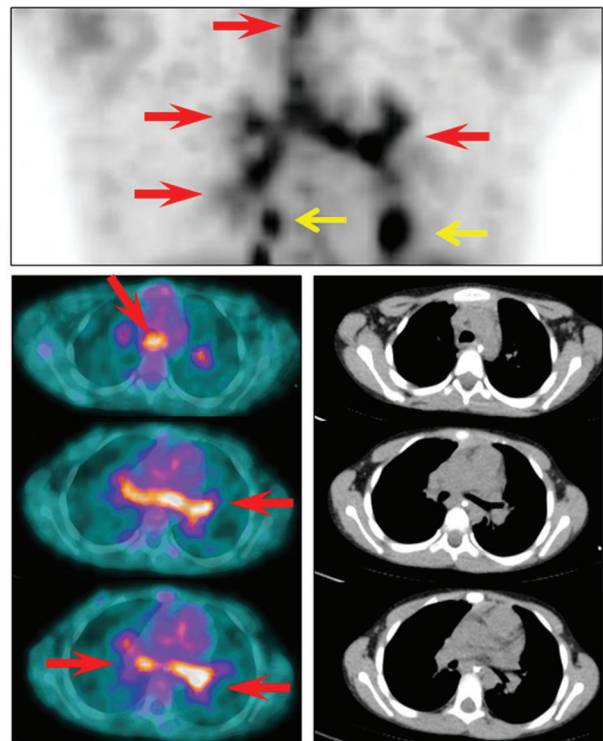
FDG PET-CT findings in a patient with tracheobronchitis. The patient reported severe coughing for 2 years. PET images demonstrated intense FDG activity throughout the tracheal and bronchial walls (red arrows), consistent with tracheobronchitis. No obvious tracheal or bronchial wall thickening was apparent on CT. Several foci of increased FDG activity in the lungs (small yellow arrows) were indicative of associated inflammatory changes in the adjacent lung parenchyma, even though the parenchymal lesions could not account for patient's persistent cough.
